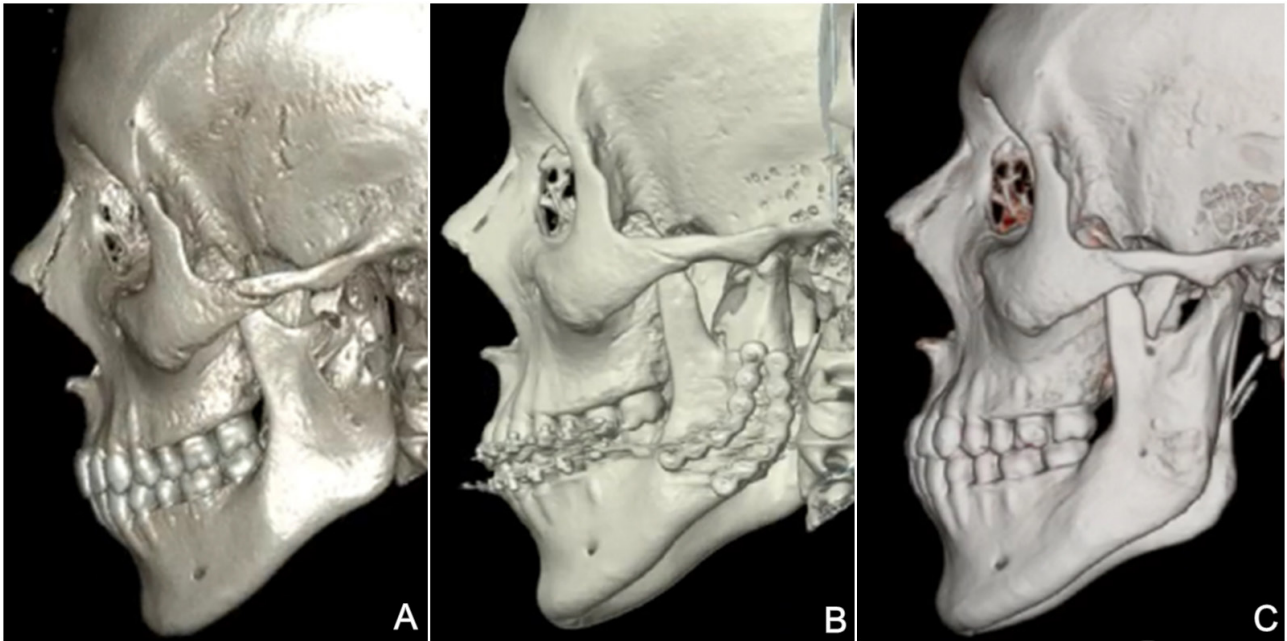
A, Three-dimensional reconstructions of the CT scans. Preoperative CT image, showing significant change in condylar anatomy and also discontinuity of the mandibular notch; B, 1-year postoperative, obtained before the removal of plates and screws; C, 2-year follow-up, showing remarkable bone remodeling, resulting in a shape similar to normal condylar anatomy.
